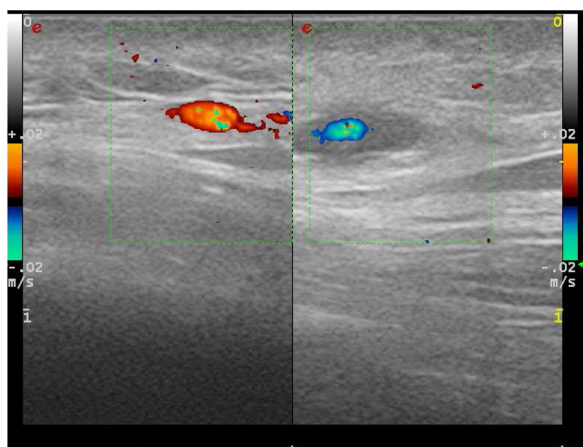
Doppler ultrasound with linear probe on palpable painful nodule. On the right, we can see a perivascular hypoechoic area corresponding to a clinical nodule. On the left, contralateral temporal artery without signs of disease.
